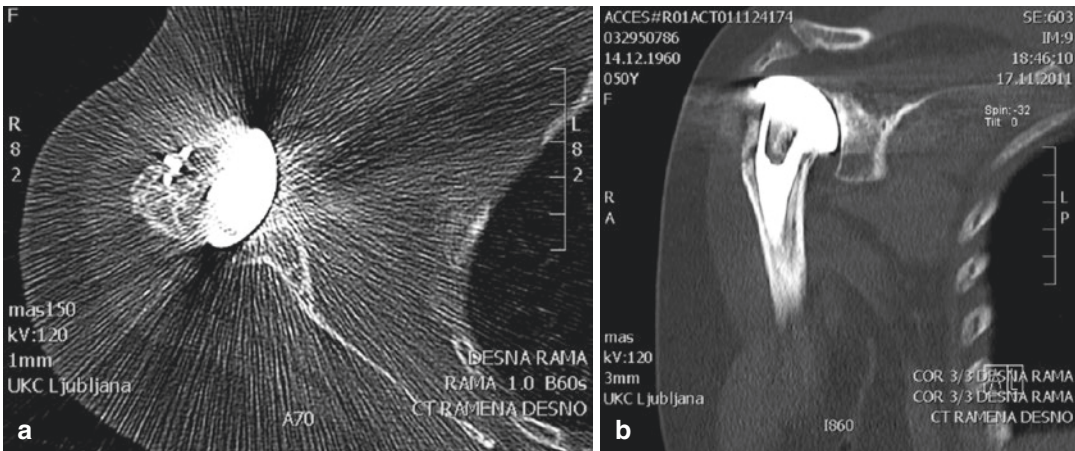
Axial (a) and coronal (b) CT scans of shoulder HA. Remnants of the tuberosities are in nonanatomical position
